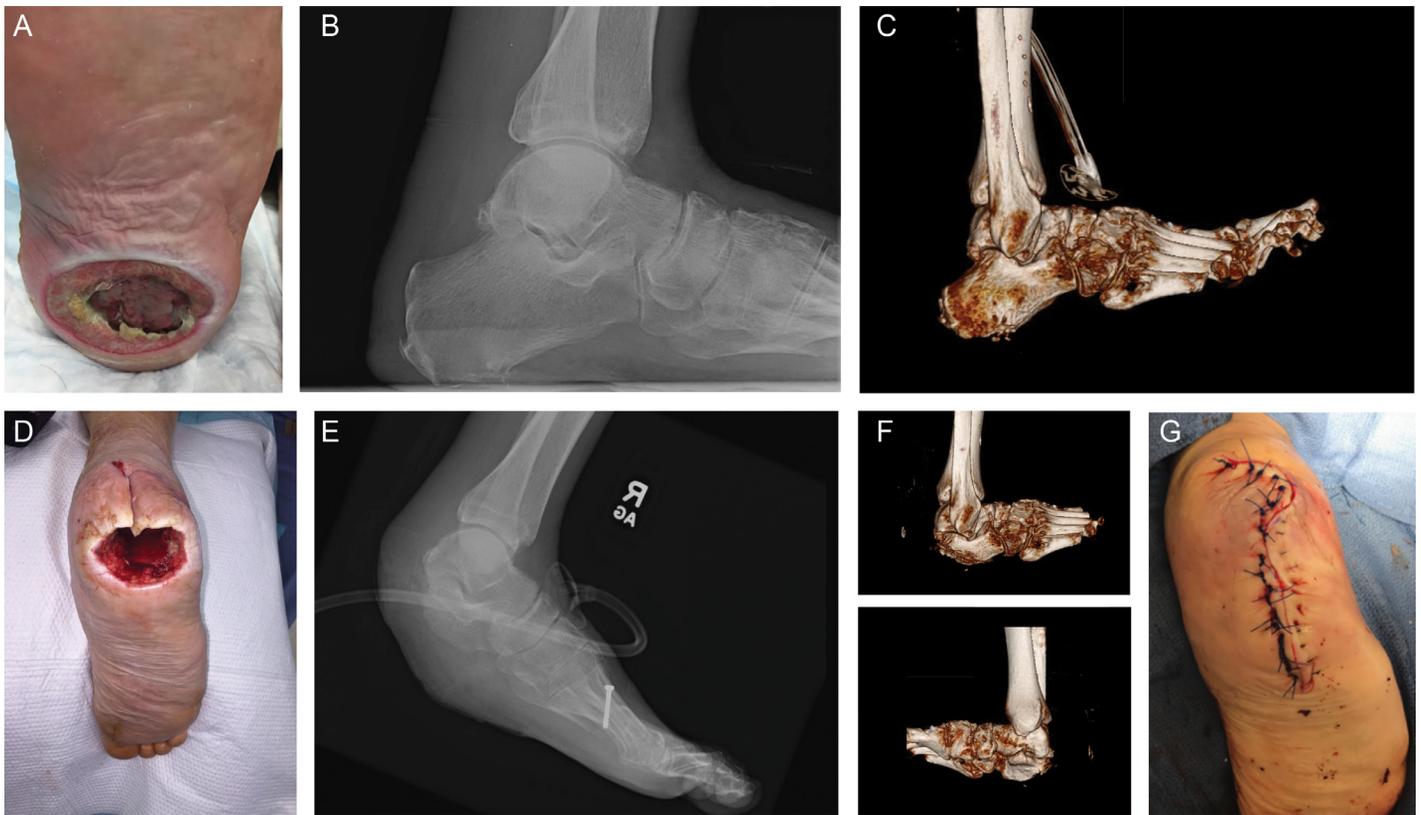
(A) Preoperative clinical picture. (B) Preoperative radiograph. (C) Preoperative computed tomographic (CT) scan 3-dimensional (3D) reconstruction. (D) Interim operative clinical picture. (E) Postoperative radiograph. (F) Postoperative CT 3D reconstruction. (G) Postoperative clinical picture.
